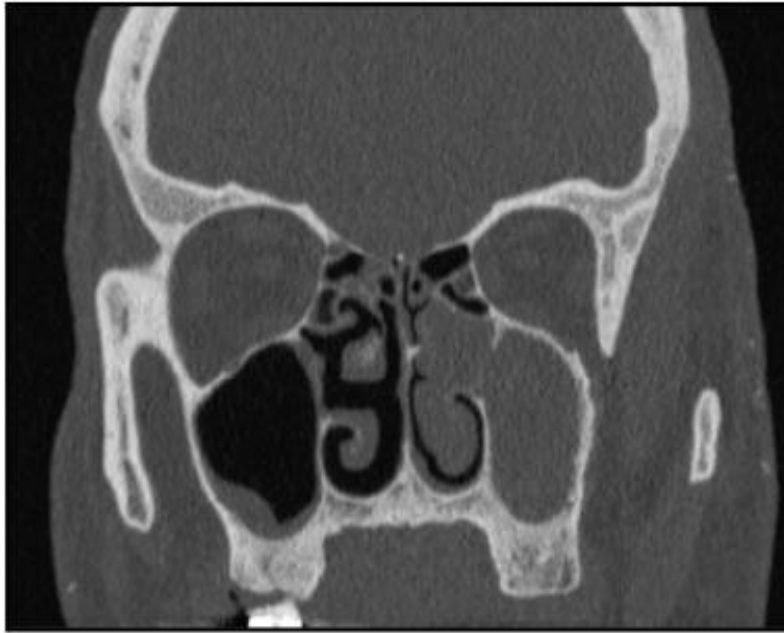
X-ray showing maxillary sinusitis. Adapted from (Maddy-Hélène Delattre, 2020)
